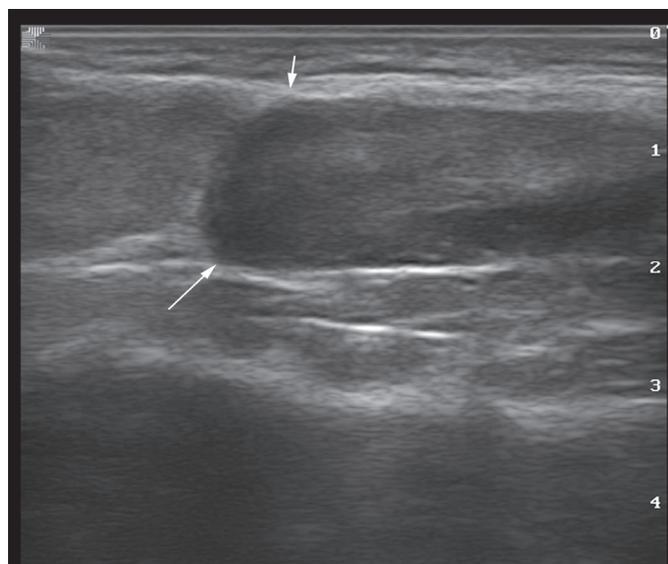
Transrectal ultrasonography of the normal prostate in a ram
